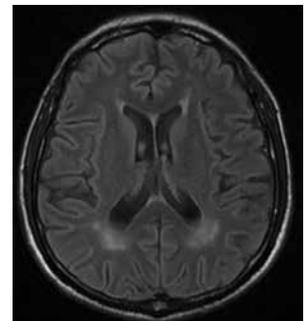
All of the white matter lesions were seen to be resorbed in the high ventricle slices of the axial FLAIR sequence taken after two months.
